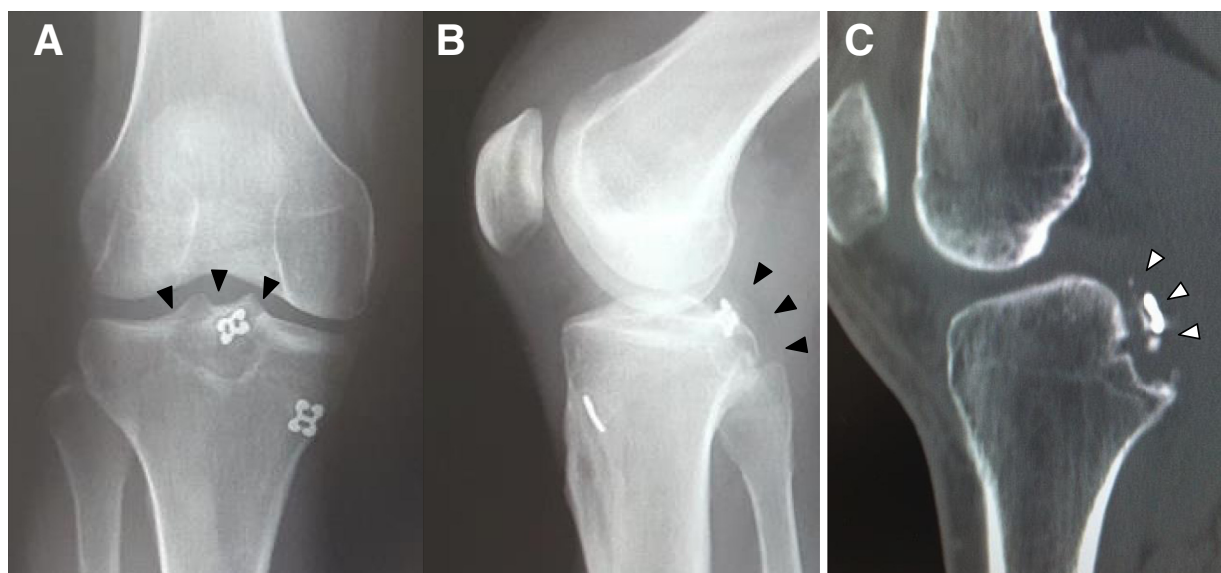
Postoperative radiographs and computed tomography scan of right knee. (A, B) Displacement of the fragment is not apparent (black arrowheads) on radiography. (C) A computed tomography scan confirmed nonunion of the fragment (white arrowheads).
